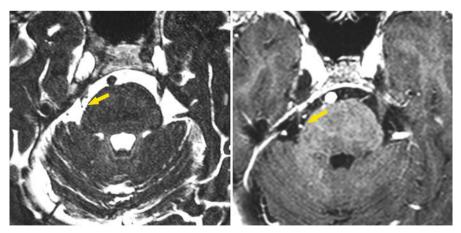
Right TN due to NVC from elongated SCA. MRI with CISS sequence (*left view*), 3D Angio MR (*right view*) and corresponding axial sections from same patient. Note loop compressing REZ at pons in medial location and distortion of the root (*arrows*)
